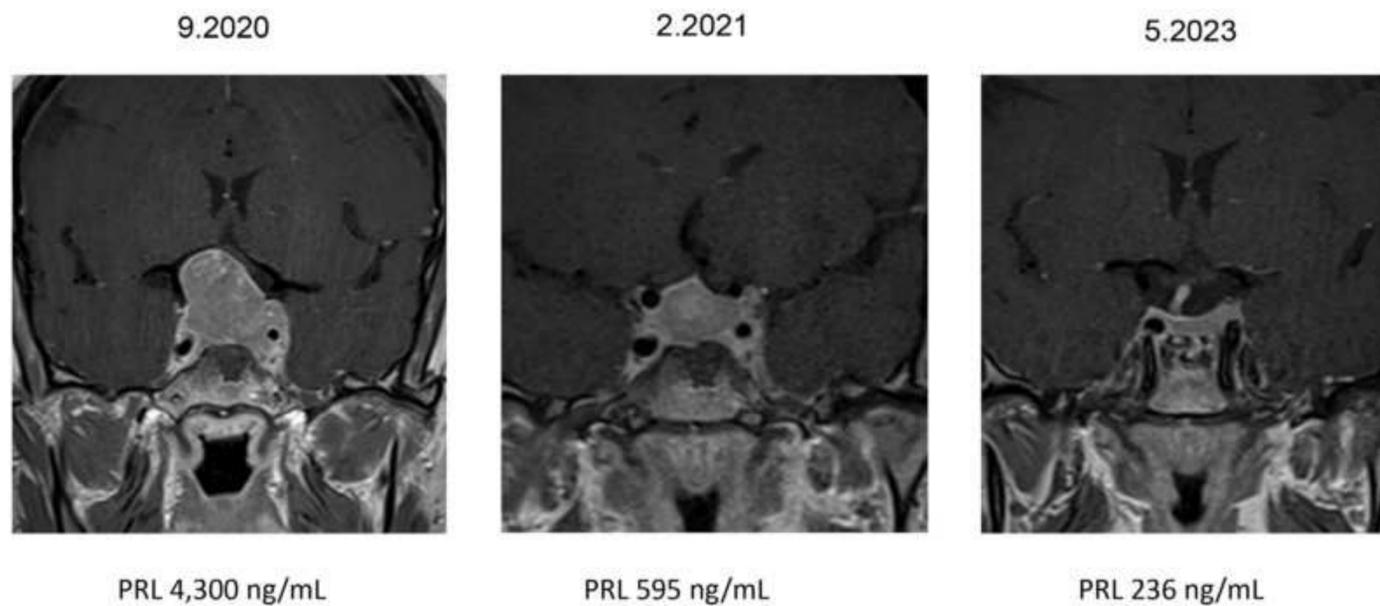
A 38 year-old male presented on 9/2020 with low libido, erectile dysfunction, and weight gain. Testosterone was very low, PRL measured 4,300 ng/mL (normal, below 20), and MRI showed a large and invasive macroprolactinoma compressing the optic chiasm. Visual field studies were compatible with bitemporal hemianopsia. Treatment with cabergoline was initiated and gradually escalated to 3.5 mg/week. PRL was significantly reduced but not normalized. Testosterone levels did not recover. This figure shows the massive tumor reduction after cabergoline treatment with visual field improvement and normalization.
